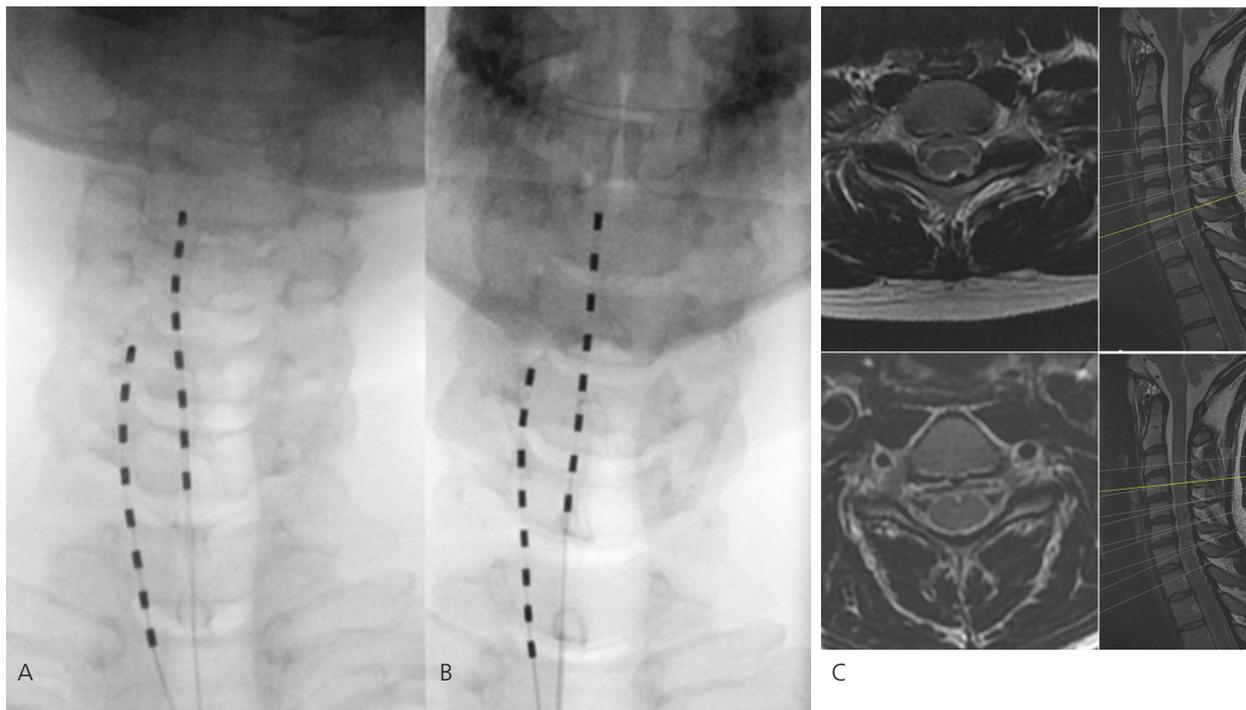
Intraoperative fluoroscopy documenting the position of the leads before (a) and after (b) the SCS revision in 2023. (c) MRI scan from November 2024 demonstrating the position of the leads in relation to the cervical spinal cord. SCS, spinal cord stimulation; MRI, magnetic resonance imaging.
